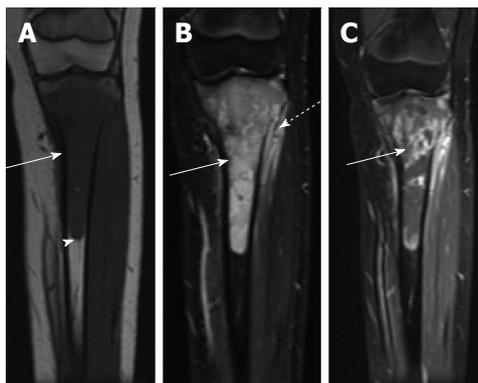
Ewing sarcoma. A: Coronal T1-weighted image of the left tibia shows a long segment of intramedullary T1 hypointensity (solid arrow). Note abrupt transition to normal marrow signal inferiorly (arrowhead); B: Coronal fast multi-planar inversion recovery image of the same patient shows very intense T2 signal in the marrow cavity (solid arrow) with extraosseous extension (dashed arrow); C: T1-weighted post-contrast image shows very heterogeneous intramedullary enhancement associated with this lesion (solid arrow).
